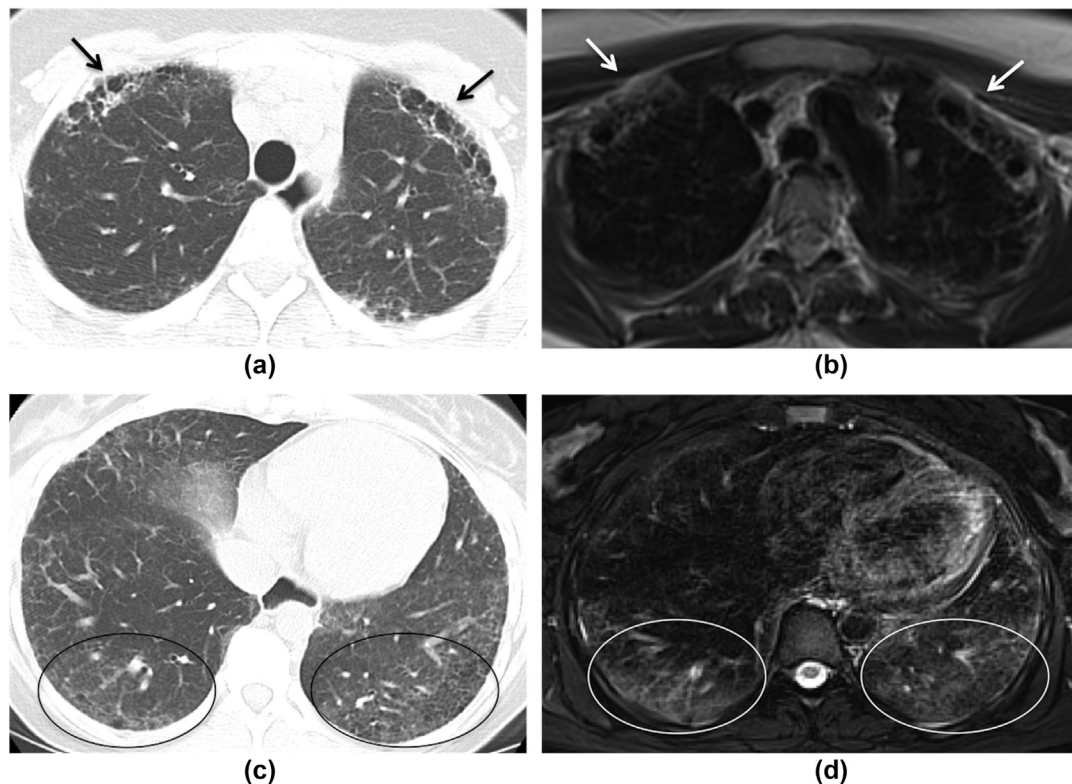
MRI allows the identification of interstitial abnormalities with similar sensitivity to that of CT. In a patient with SSc, honeycombing (arrows in a and b) and ground-glass opacities (circles in c and d) are adequately depicted in both CT (a, c) and MRI images (b: fast spin echo T2-weighted image; d: fast spin echo fat-saturated T2-weighted image).
